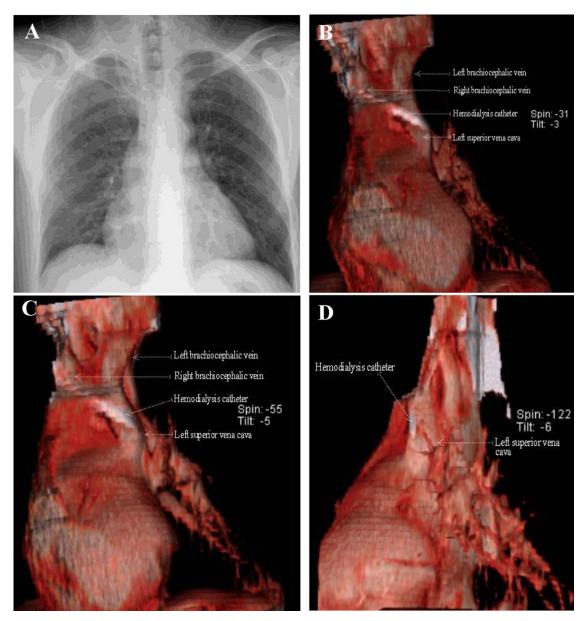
(A) Posteroanterior chest X-ray shows that the right internal jugular vein catheter is crossing the upper mediastinum from right to left. (B–D) Anterior, anterolateral, and lateral views of three-dimensional reconstruction of thorax computed tomography without contrast enhancement show that the right brachiocephalic vein fuses with the left brachiocephalic vein to form the left superior vena cava, and the catheter is spontaneously enhanced within the right brachiocephalic vein and the left superior vena cava; the right superior vena cava is absent.
